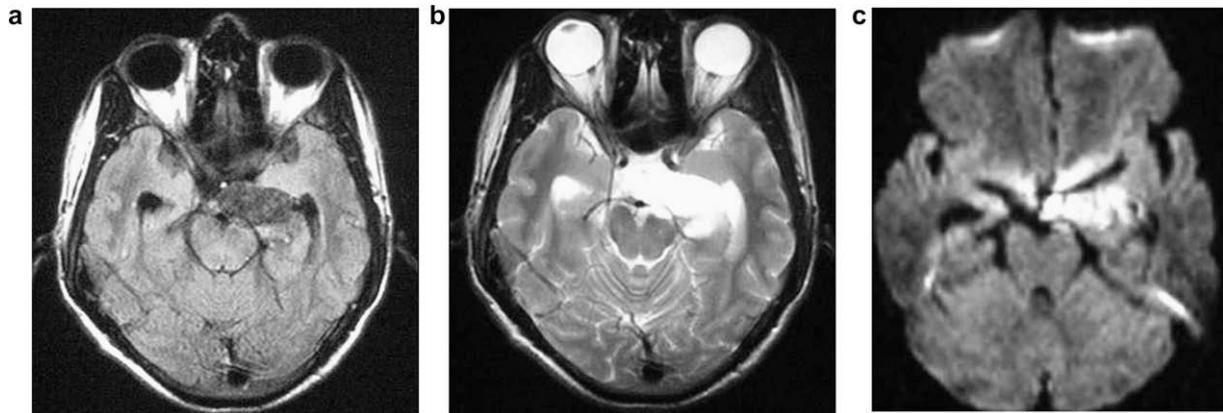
(a) Axial fluid-attenuated inversion recovery MRI, (b) axial T2-weighted MRI, and (c) axial diffusion-weighted MRI of the patient showing the medial temporal epidermoid tumor that extended towards the suprasellar region.
